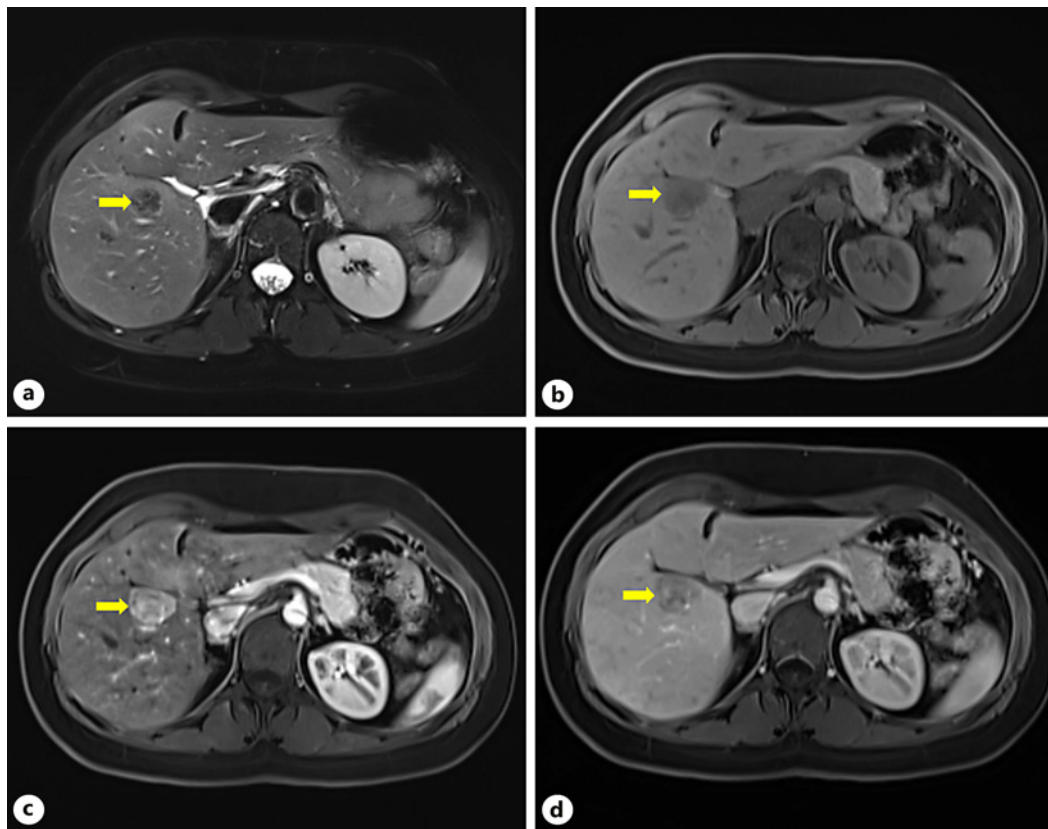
Hepatic MRI: slightly hyperintense nodule (arrow) on T2 (a) and hypointense on T1 (b), measuring 30 mm, with an internal nodular area measuring 17 mm. c, d The dynamic study showed hyper-vascularity of the lesion, with arterial phase enhancement and washout in the portal phase.
